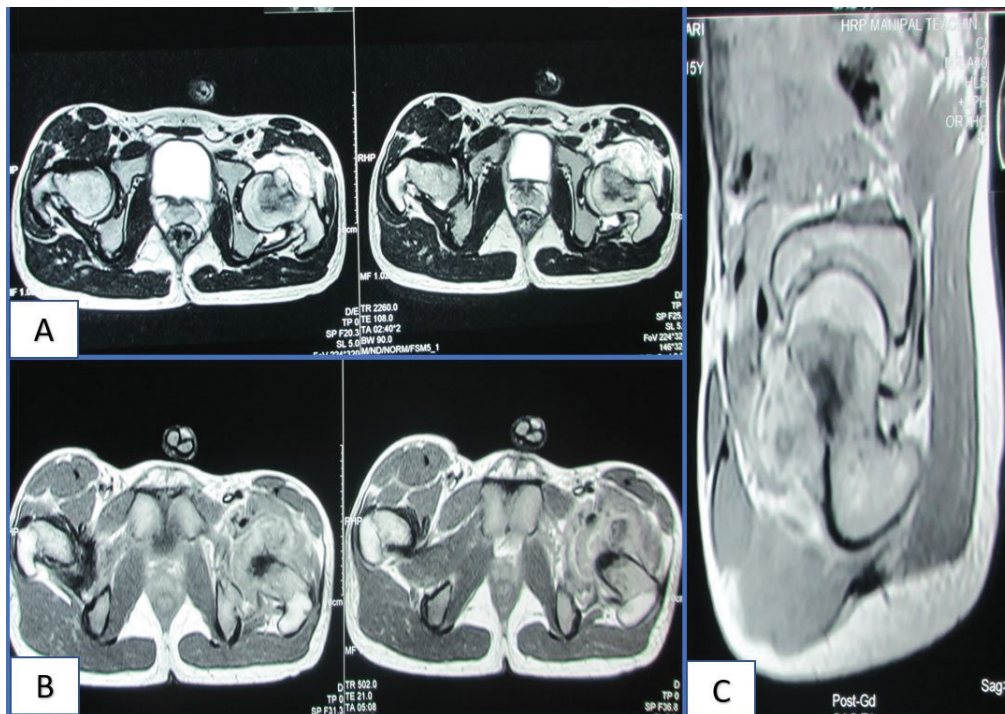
MRI T2W images show heterogeneous signal intensity lesion with areas of sclerosis involving the femoral head and neck. The large associated soft tissue in the anterior aspect appears predominantly hyperintense on T2W images (A). Post-contrast axial (B) and sagittal (C) images show heterogeneous enhancement with areas of necrosis involving soft tissue.
